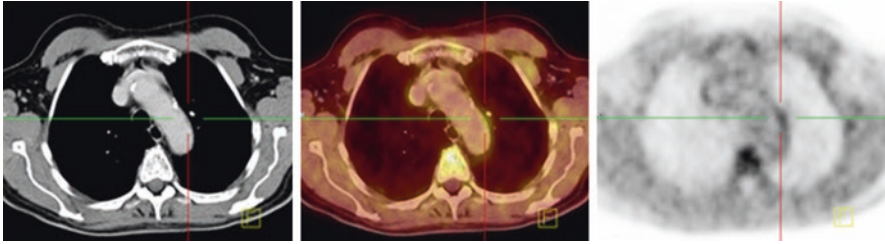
Example of arterial ^{18}F -choline uptake and calcifications representative transaxial ^{18}F -choline-PET/CT results: partially calcified atherosclerotic plaque within the aortic arch which accumulates ^{18}F -choline mainly in the non-calcified part in a 62-year-old (Forster et al. 2010). (a) (From left to right) CT image; (b) PET/CT fusion; (c) PET image
